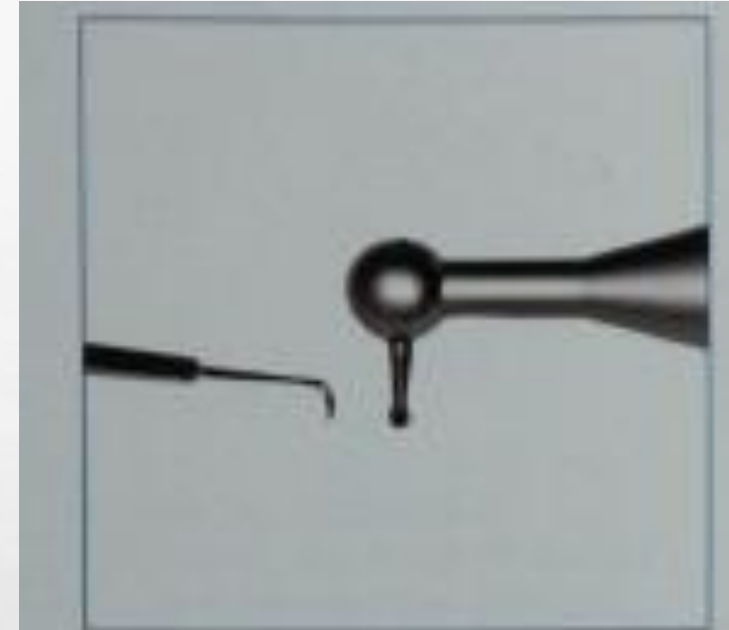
A great difference in size can be seen between the ultrasound microbp and the older low-speed microhead.
